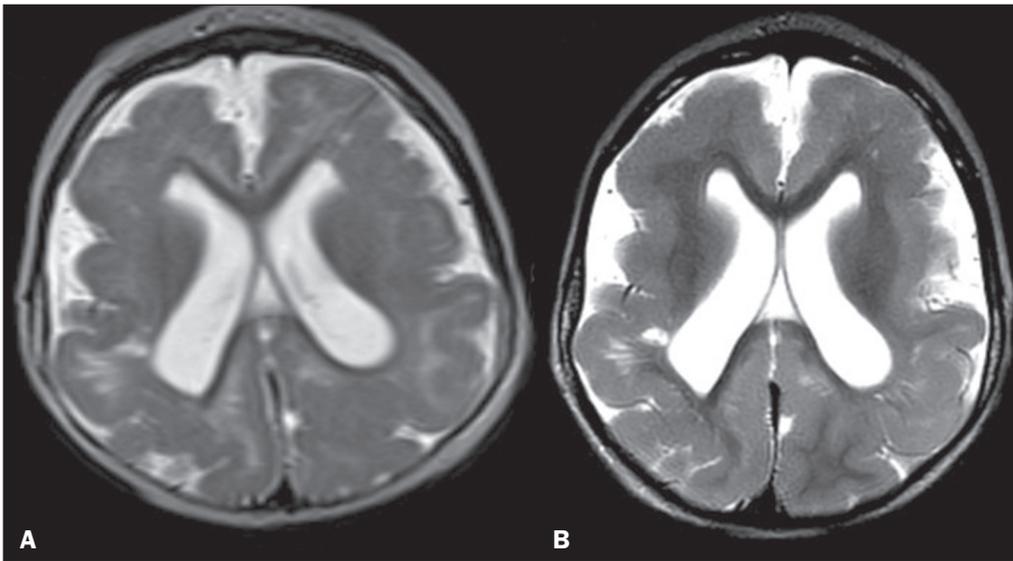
Persistent foci of hyperintensity in the periventricular white matter and areas of pachygyria and polymicrogyria interspersed in the frontal lobes on axial T2-weighted images from the first MRI at 10 months of age (A), similar to the second MRI at 19 months (B).
